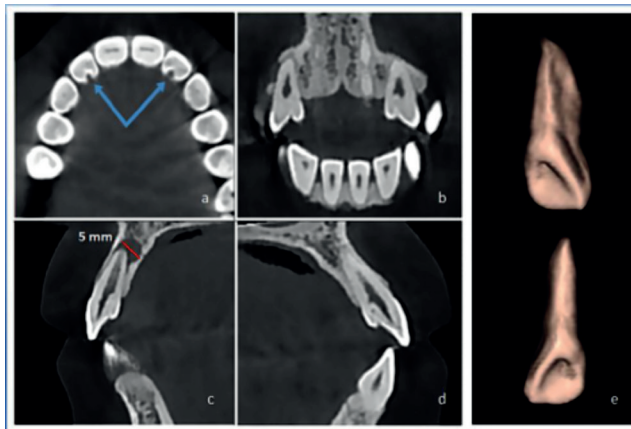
Cone beam computed tomography sections (a, b, c, d) (blue arrows show invagination, red line shows diameter of lesion), e) 3D images of maxillary lateral teeth
